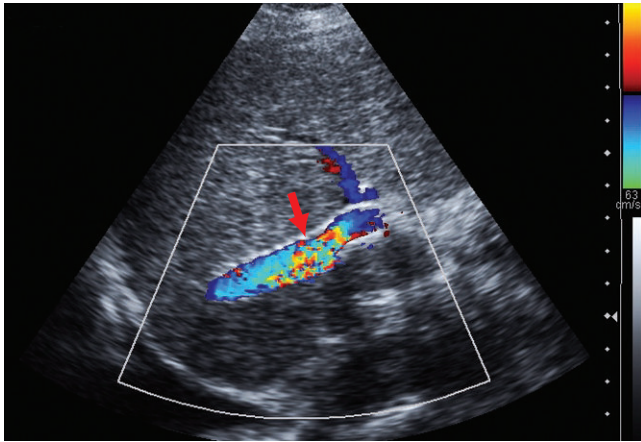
The longitudinal color Doppler image of the stent graft shows focal aliasing in the mid aspect of the stent graft (arrow) suggestive of a stenosis.
